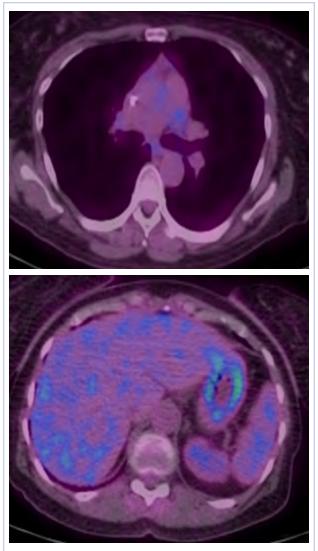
PET-CT of A, chest showing resolution of hypermetabolic lesions, and B, resolution of hypermetabolic lesions, physiologic uptake of FDG in liver.
